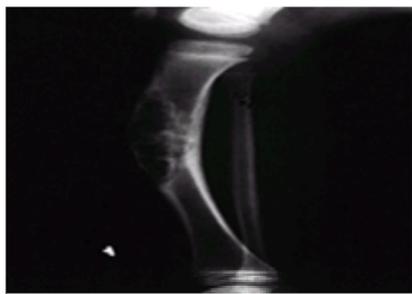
Lateral radiograph of the leg of a patient with osteofibrous dysplasia. Found almost exclusively in the tibia, this lesion involves the anterior cortex, and can extend into the medullary canal. The tibia commonly has an anterior bow.
